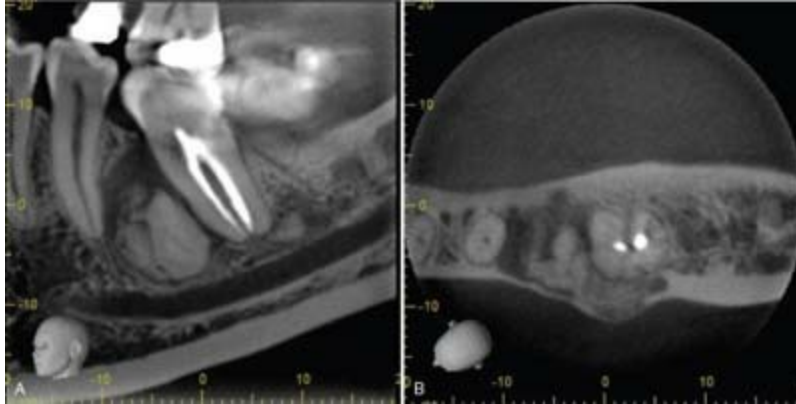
Focal cemento-osseous dysplasia. A, Sagittal CBCT image demonstrating a mixed-density lesion with a low-density periphery between the mandibular second premolar and first molar. A second high-density lesion is present near the distal root apex of the first molar. B, Axial CBCT image exhibiting an expanded and thinned cortex from a mixed-density central globular mass with a hypodense periphery.
